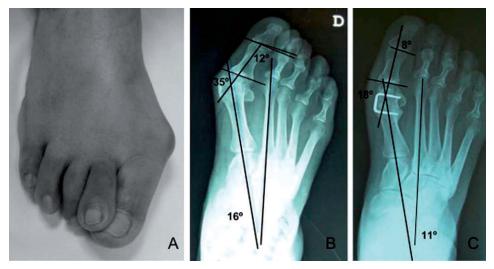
A) 65-year-old woman, right foot. B) Pre-op radiographic study. C) Surgical technique associated to the Regnauld technique: distal osteotomy. Final evolution at 2 years with a 17° improvement in the metatarsophalangeal, a 5º improvement in the intermetatarsal angle and a 4º improvement in the distal articular angle. Scale of the American Orthopaedic Foot and Ankle Society: 93 points, excellent subjective assessment.
